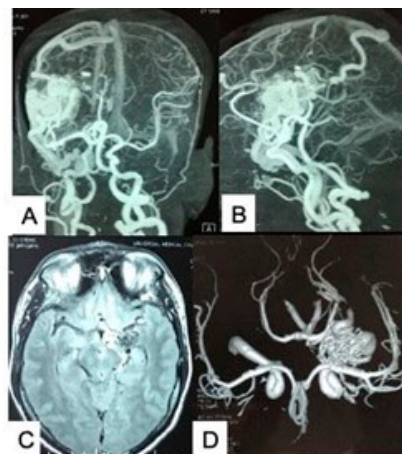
(A,B) CT angiogram showing a compact Sylvian fissure AVM fed by branches from the MCA and venous drainage toward the superior sagittal sinus. (C,D) MRA revealing a mesial temporal AVM fed by branches from the PCOM and anterior choroidal artery. Source: Figure by authors.
